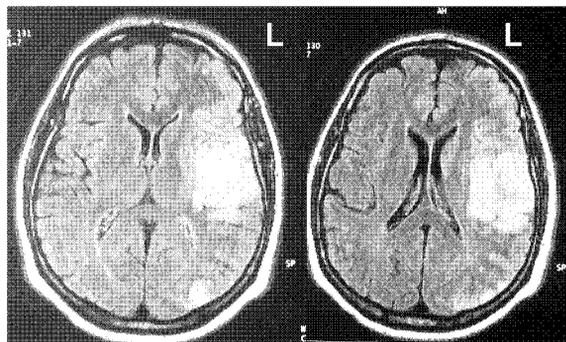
MRI head scan for BB showing large lesion in the left perisylvian region.
